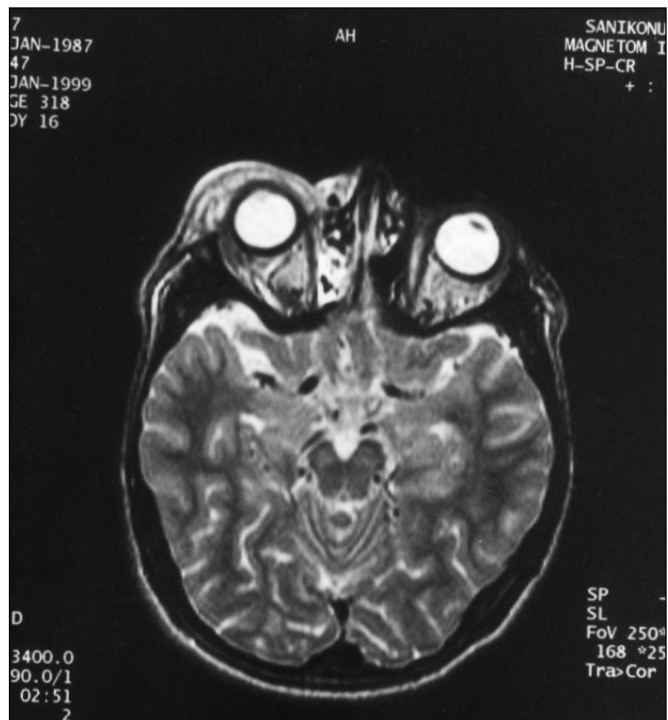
Magnetic resonance imaging shows unilateral right lacrimal gland enlargement.
